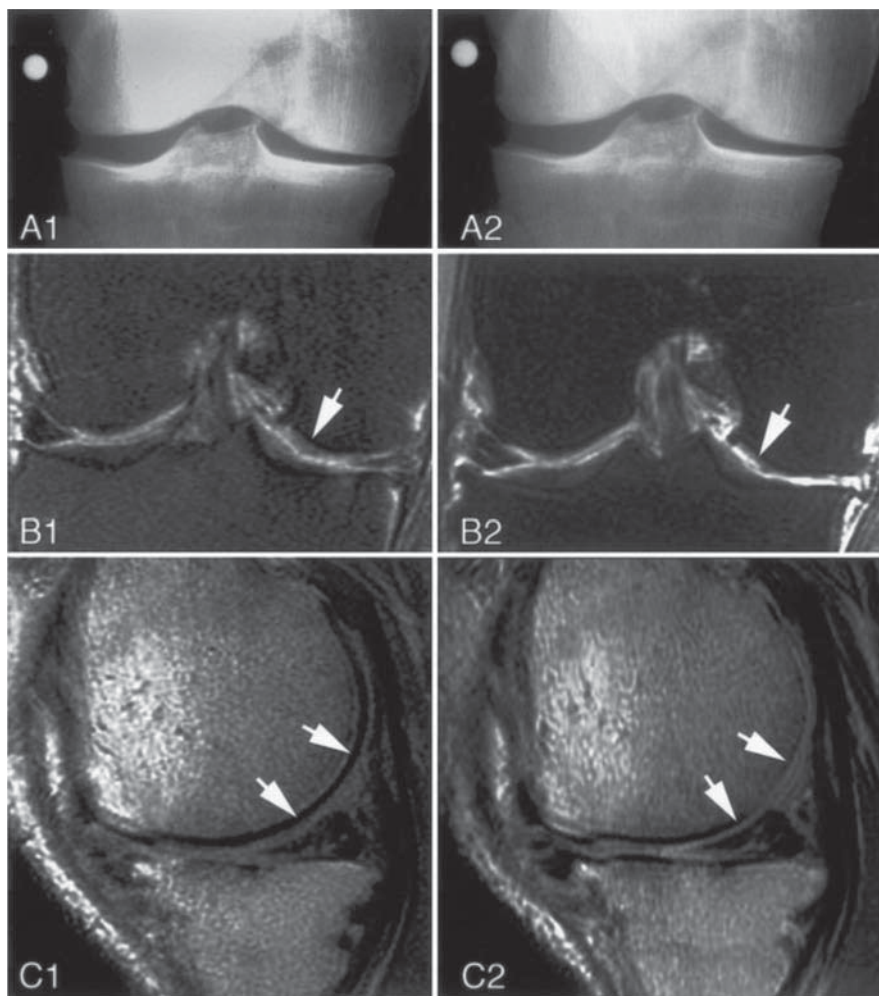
Example of medial compartment cartilage loss without radiographic progression. (A) Baseline (A1) and 30-month follow-up (A2) semiflexed, weight-bearing knee radiographs. (B) Corresponding magnetic resonance image of the same knee with spin-echo, fat-suppressed and T2-weighted coronal views at baseline (B1) and follow-up (B2). (C) Spin-echo, proton-density and T2-weighted sagittal views at baseline (C1) and 30-month follow-up (C2). Arrows indicate areas of cartilage loss. Source: Amin *et al.* (2005).
